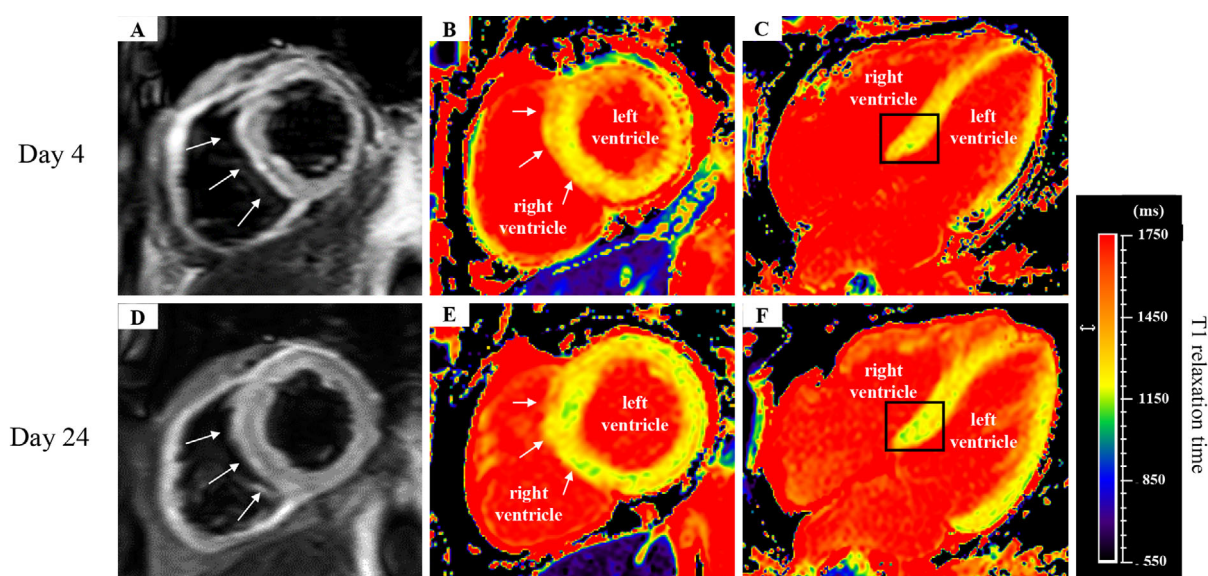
CMRI findings for Case 1. (A-C) Initial CMRI performed on day 4. These figures depict the STIR and increased T2 signal (A); T1 relaxation time was prolonged due to myocardial edema at the onset of myocarditis (B, C). (D-F) Second CMRI examination performed on day 24. Following immunosuppressive therapy, the STIR T2 signal had decreased (D) and the T1 relaxation time shortened (E, F) compared with before myocarditis treatment, indicating improvement of myocardial edema. CMRI: cardiovascular magnetic resonance imaging, STIR: short tau inversion recovery
